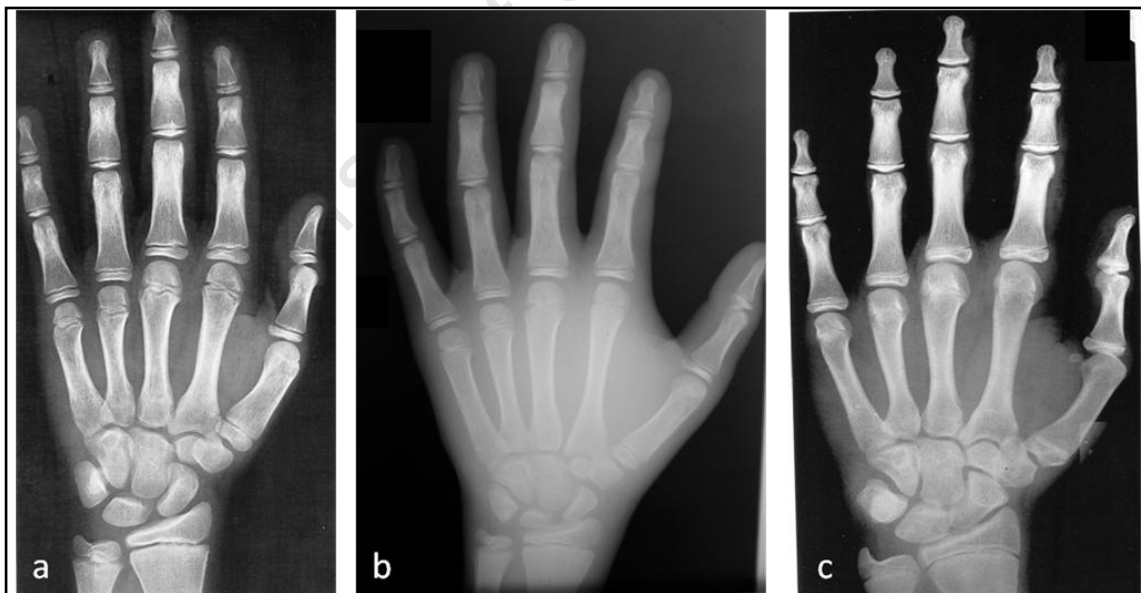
Female individual whose skeletal age was over estimated. Radiograph (a) is GP Standard radiograph for a 14 year old female. Radiograph (b) is the radiograph for individual GSF036. This individual's chronological age was 13.8 years. Radiograph (c) is GP Standard radiograph for a 15 year old female. Notice that in (b) epiphyseal fusion is complete in the distal metacarpals and in the phalanges and fusion is more advanced in the radius making radiograph (c) more representative of the level of skeletal development
